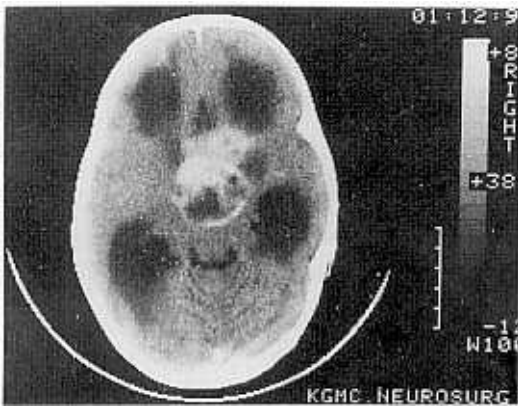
CT scan head showing a suprasellar enhancing high attenuating lesion with multiple intratumoral cysts.
